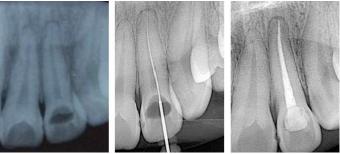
Pre-op, IAF and post-op X-rays.
